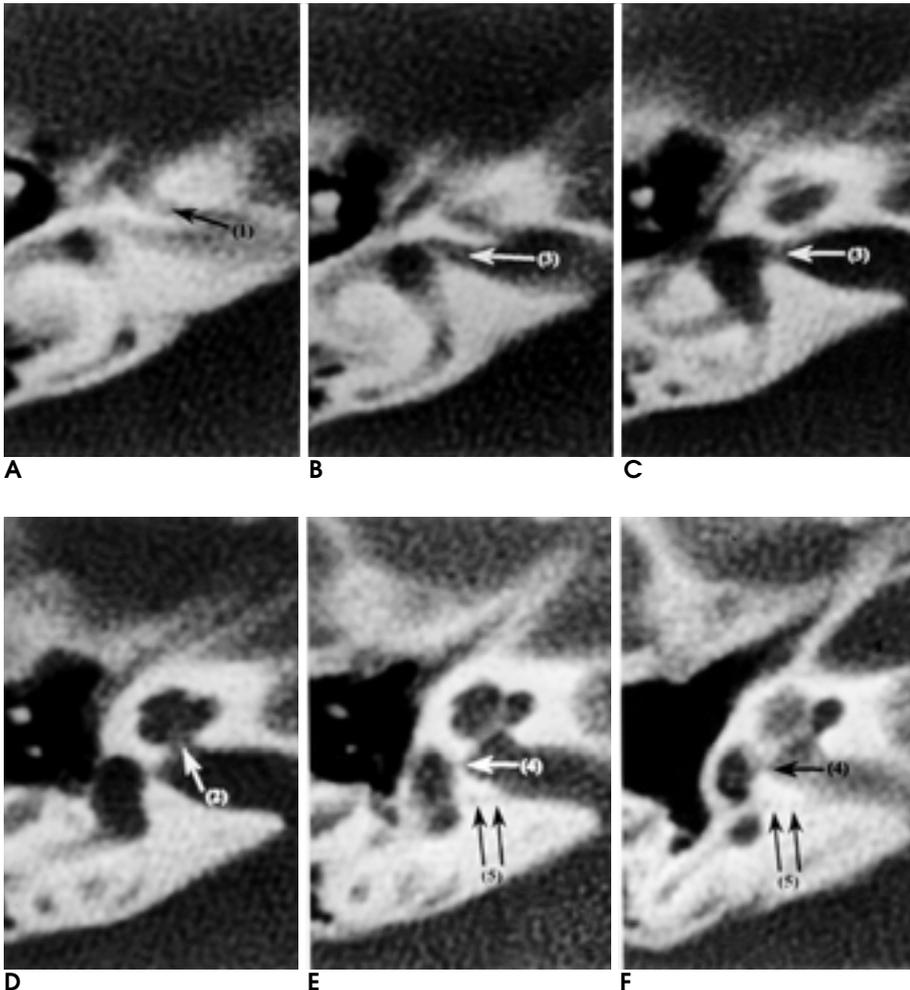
A-F. Serial contiguous axial images of high-resolution temporal CT with edge-algorithm. Arrows indicate bony canals for labyrinthine segment of facial nerve (1), cochlear nerve (2), superior vestibular nerve (3), saccular branch (4) and posterior ampullary nerve(5) of inferior vestibular nerve.
